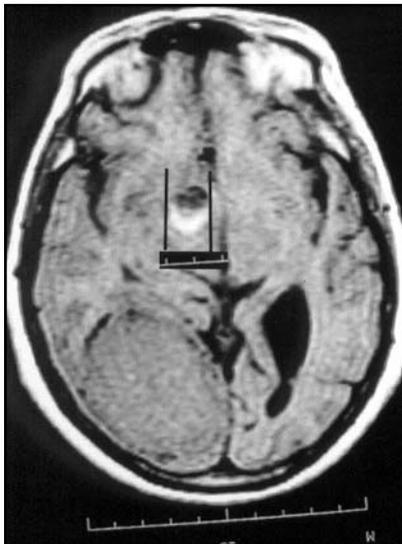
Magnetic resonance imaging. Aneurysm of the anterior territory measuring 18 mm x 12 mm.
